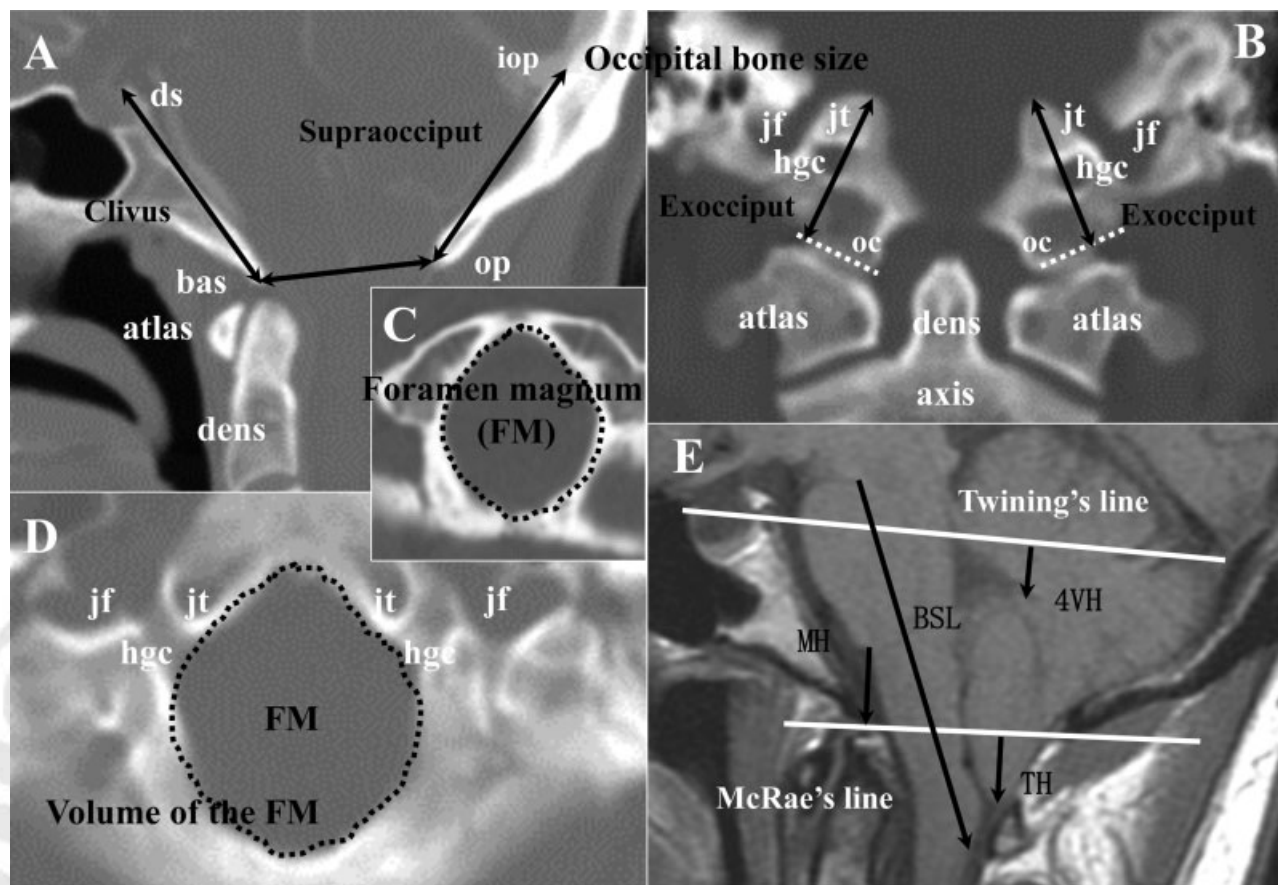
Morphometric analysis of the posterior cranial fossa. (A) Two-dimensional (2D) reconstructed computed tomography (CT) sagittal image demonstrating morphometric measurements of the basiocciput, supraocciput, and anterior–posterior diameter of the foramen magnum (FM). (B) 2D reconstructed coronal image demonstrating morphometric measurements of the exocciput. (C) 2D reconstructed CT image demonstrating the area of the inferior outlet of the FM at the level of the basion and opisthion. (D) 2D reconstructed CT image demonstrating the area of the superior outlet of the FM at the level of the jugular tubercle. (E) Magnetic resonance midline sagittal image demonstrating morphometric measurements of the brain stem and cerebellum, medullary height (MH), and the position of the fourth ventricle. ds, top of the dorsum sellae; hgc, hypoglossal canal; iop, internal occipital protuberance; jf, jugular foramen; jt, jugular tubercle; oc, occipital condyle; ts, tuberculum sellae. Twining's line: the line between the tuberculum sellae and internal occipital protuberance. Using reconstructed 2D-CT and magnetic resonance imaging scans of the head, the size of the occipital bone was determined by measuring its enchondral parts (exocciput, basiocciput, and supraocciput), which enclose the posterior cranial fossa (→ Fig. 1). Measurements included the axial length of the clivus (basiocciput and supraocciput) from the top of the dorsum sellae to the basion; the axial length of the supraocciput from the center of the internal occipital protuberance to the opisthion; and the axial length of the occipital condyle (exocciput) from the top of the jugular tubercle to the bottom of the occipital condyle and the supraocciput (distance between the opisthion and the center of the internal occipital protuberance); these three measurements were unified as occipital bone size. The volume of the surrounding area of the foramen magnum was defined as the sum total of areas on two levels: (1) the inferior outlet between the basion and opisthion; and (2) the superior outlet at the level of the top of the jugular tubercles. The axial length of the brain stem was measured between the midbrain-pons junction and medullocervical junction. MH was defined as the vertical distance between the pontomedullary junction and foramen magnum. The position of the fourth ventricle was defined as the vertical distance between the top of the fourth ventricle and Twining's line. TH means the length of herniation of the cerebellar tonsils. Radiographic analysis software (Osirix; free access) was used for measurements and calculations.
